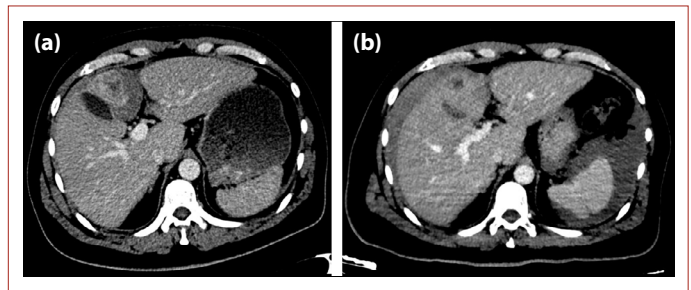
Contrast enhanced CT obtained one day before the admission (a) and at the day of admission (b) shows hypervascular tumor located in segment IV. An increase in the amount of perihepatic fluid consistent with hemorrhagic fluid is seen in these serial CT examinations.
